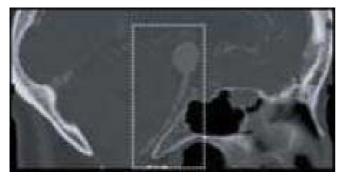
Slice image from CT used for 3D reconstruction.
